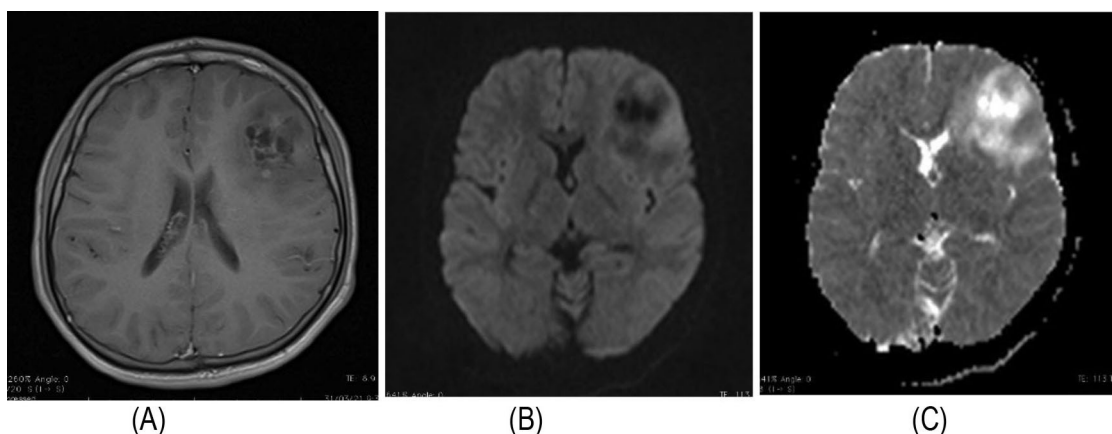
Axial post contrast T1W image of low-grade glioma which appears as heterogeneously mildly enhancing altered signal intensity lesion in left frontal region (A), dark on DWI (B) and bright on ADC (C)
